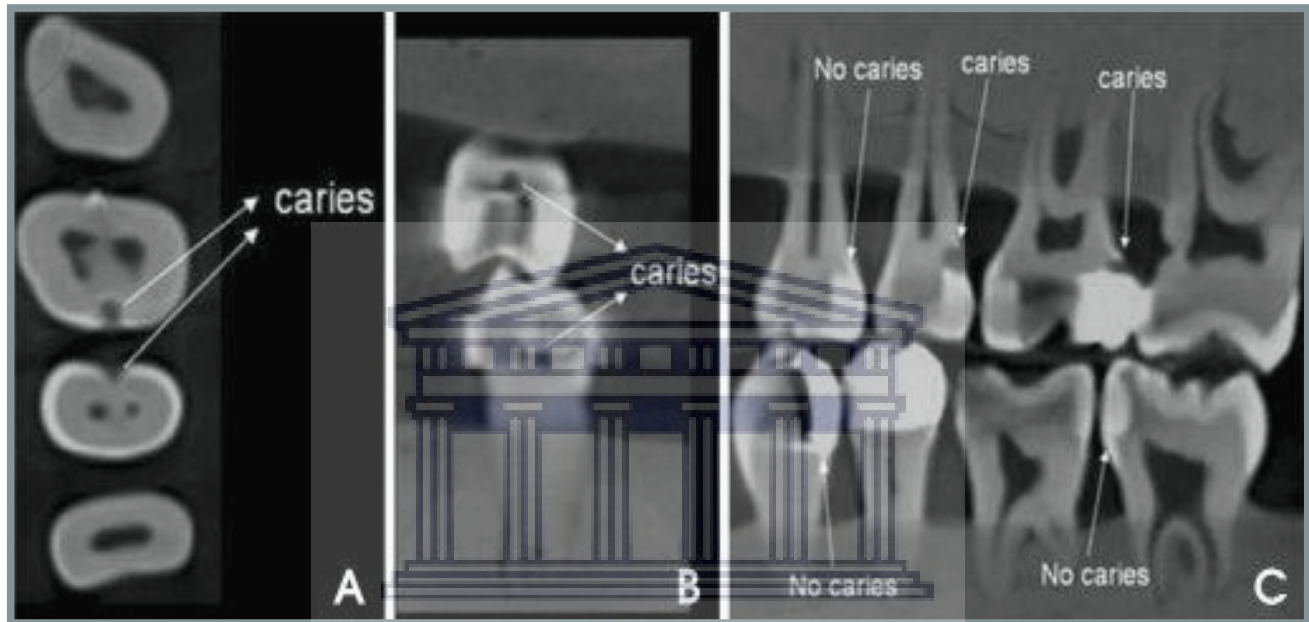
CBCT image (https://www.researchgate.net/publication/221736175_Diagnostic_performance_of_cone-beam_computed_tomography_on_detection_of_mechanically-created_artificial_secondary_caries/figures?lo=1)
